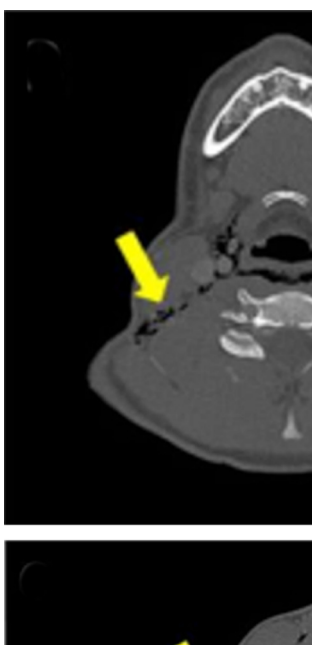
Computed tomography (CT) images of the neck (A, B) and chest (C) show air diffusely throughout mediastinum and interspersed between mediastinal structures. The CT scan showed no evidence of tracheal or oesophageal abruption
